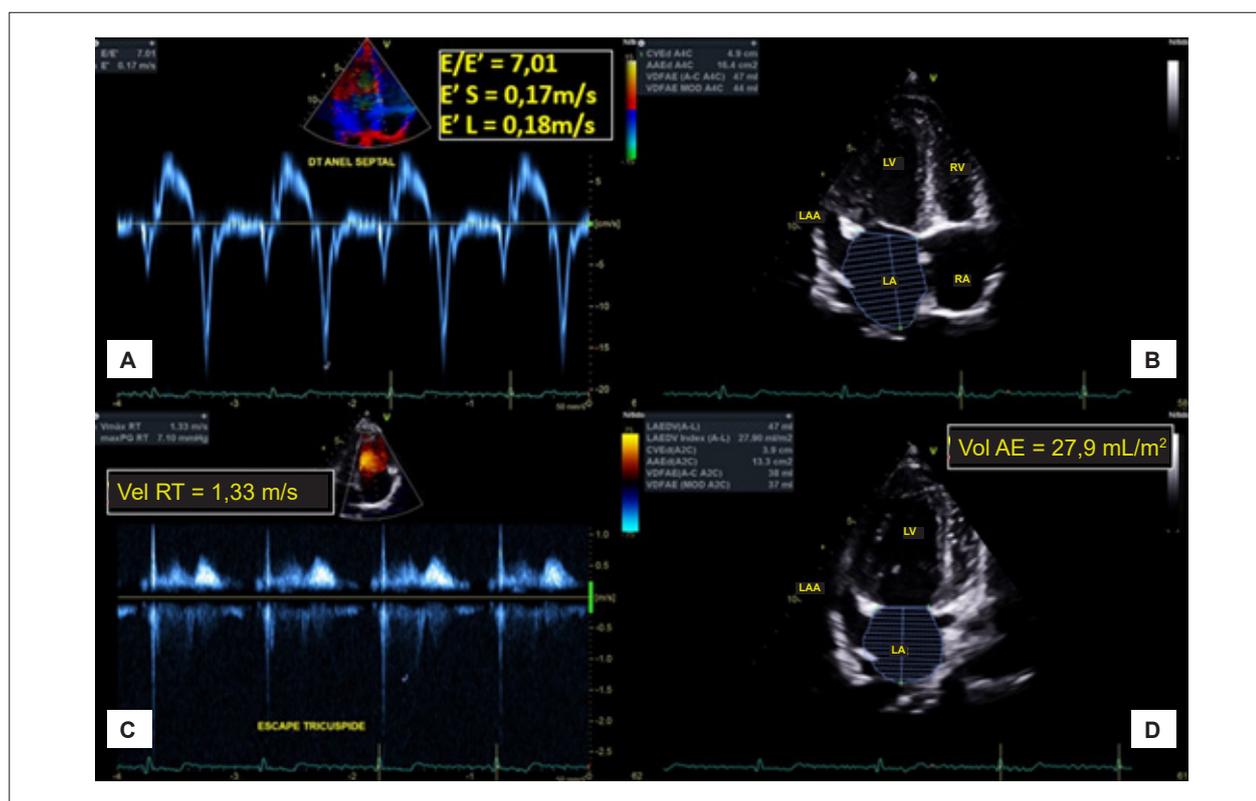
A) mitral annular tissue Doppler; B) apical four-chamber view on 2D echo bidimensional; C) continuous Doppler of tricuspid regurgitation; D) apical two-chamber view on 2D echo. LAA: left atrial appendage; RA: right atrium; LA: left atrium; E'L: lateral e' velocity; E'S: septal e' velocity; RV: right ventricle; LV: left ventricle; Vol AE: left atrium indexed volume.
